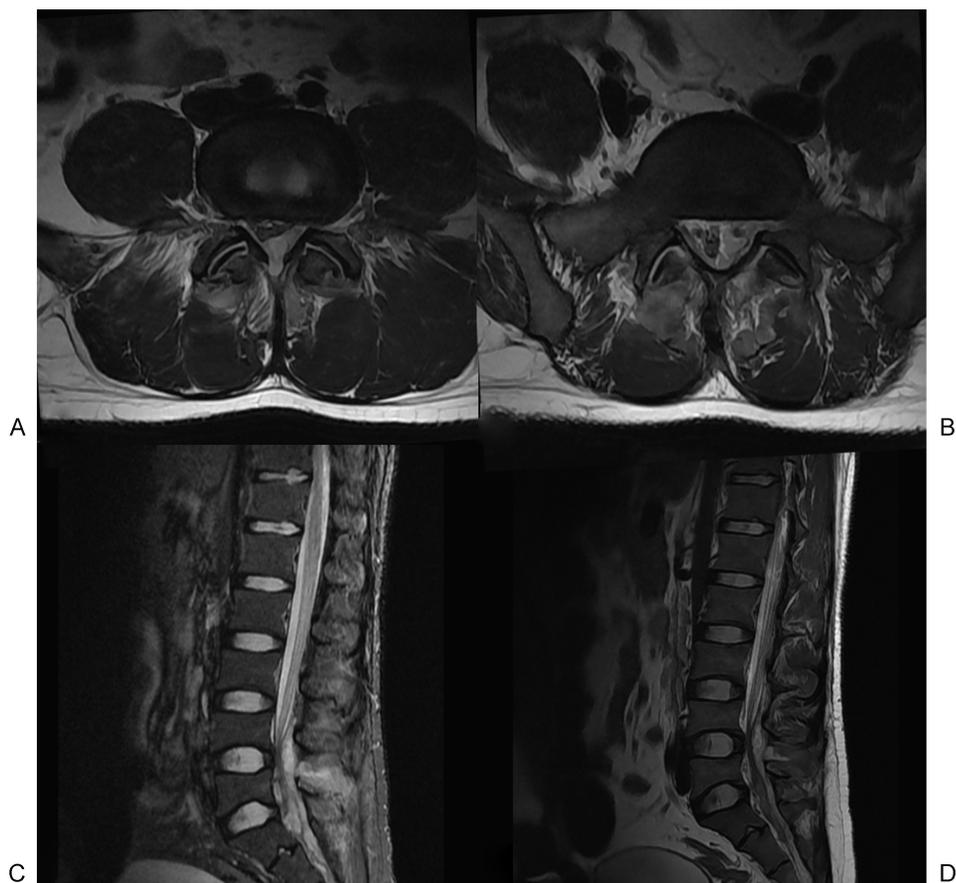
Axial T2-weighted images (A, B) showing spina bifida of L4 and paraspinal muscle soft tissue hyperintensities, sagittal images (C, D) showing displacement of the dura and cauda equina anteriorly by T2 hyperintense collection. The L4/L5 interspinous ligament is showing hyperintensities.
